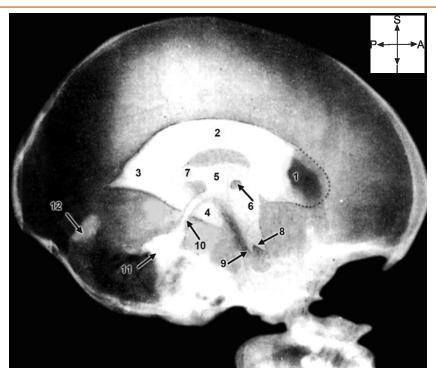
Ventriculogram. Lateral view. A radiograph of the head was taken after injecting a radiopaque dye into the ventricular system. The parts of the lateral ventricle seen are (1) anterior horn (part of which appears dark as air has entered it during injection), (2) central part, (3) posterior horn, and (4) inferior horn. In relation to the third ventricle, the structures seen are (5) suprapineal recess, (7) optic recess, (8) and infundibular recess (9). Interthalamic connexus is seen as a dark area (6). Other structures seen are aqueduct (10) and fourth ventricle (11). Some dye that has reached the cisterna magna through the apertures of the fourth ventricle is also seen (12)
